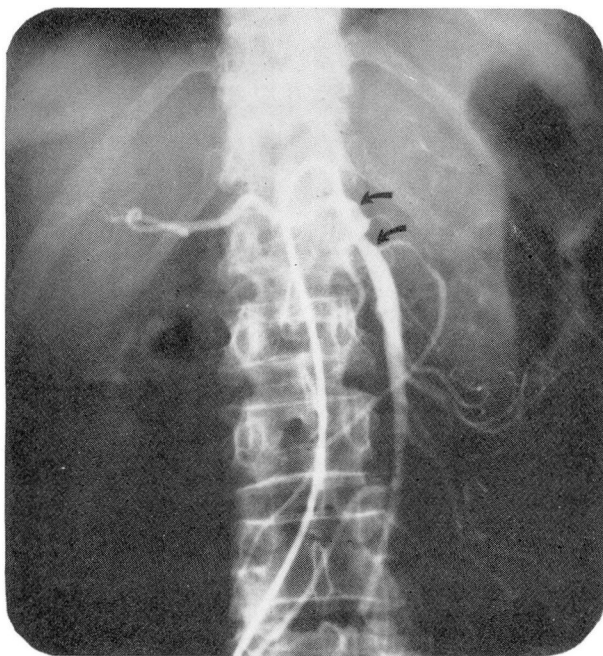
Roentgenogram showing encasement of the proximal part of the superior mesenteric artery. The hepatic artery, which branches off the superior mesenteric artery, is also encased.
